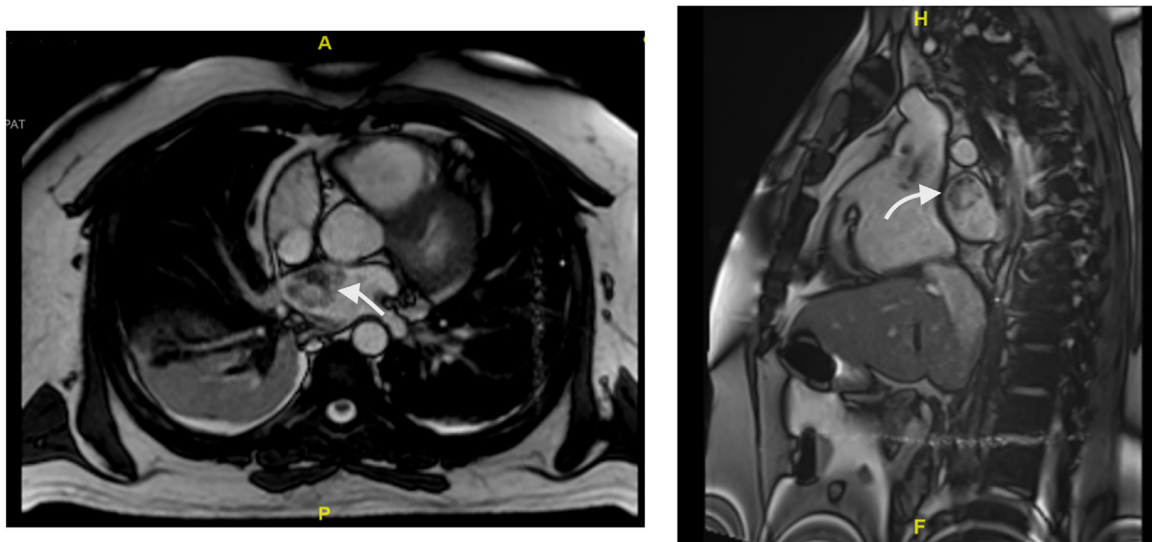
Cardiac MRI. Cardiac MRI showing a left atrial myxoma in axial T2 Steady-State Free Precession (T2-TRUFI) sequence (A) and sagittal T2-TRUFI sequence (B) as indicated by the white arrows. The lesion is heterogenous, displaying signals of varying intensity and measuring around 2.4 × 3.3 cm along its axial and craniocaudal axes, respectively. It is fairly defined, confined to the left atrium and attached to the interatrial septum.
